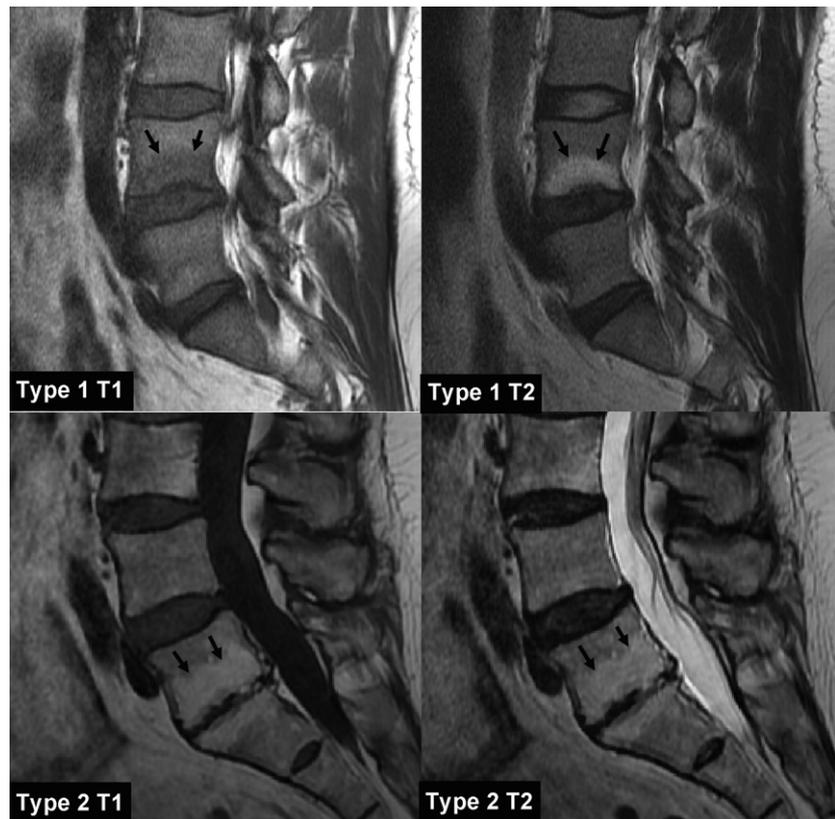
Type 1 and Type 2 Modic changes in T1- and T2-weighted sagittal magnetic resonance imaging scans. Images kindly provided by Dr. Tim Maus, Rochester, Minnesota.
